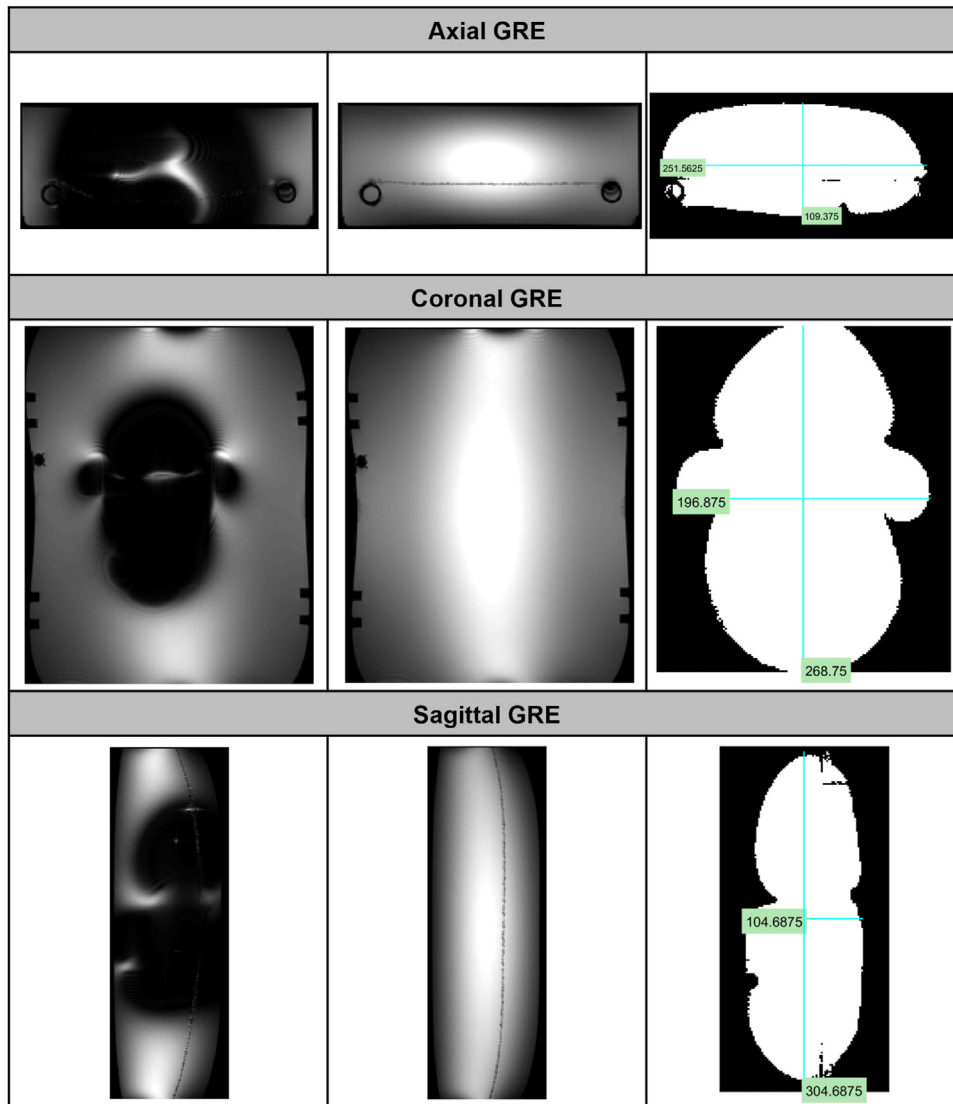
CoCr knee with a gradient echo pulse sequence in a 3T MRI system. Worst-case image (left), background image (middle), resulting image artifact (right). Measurements are in millimeters.
